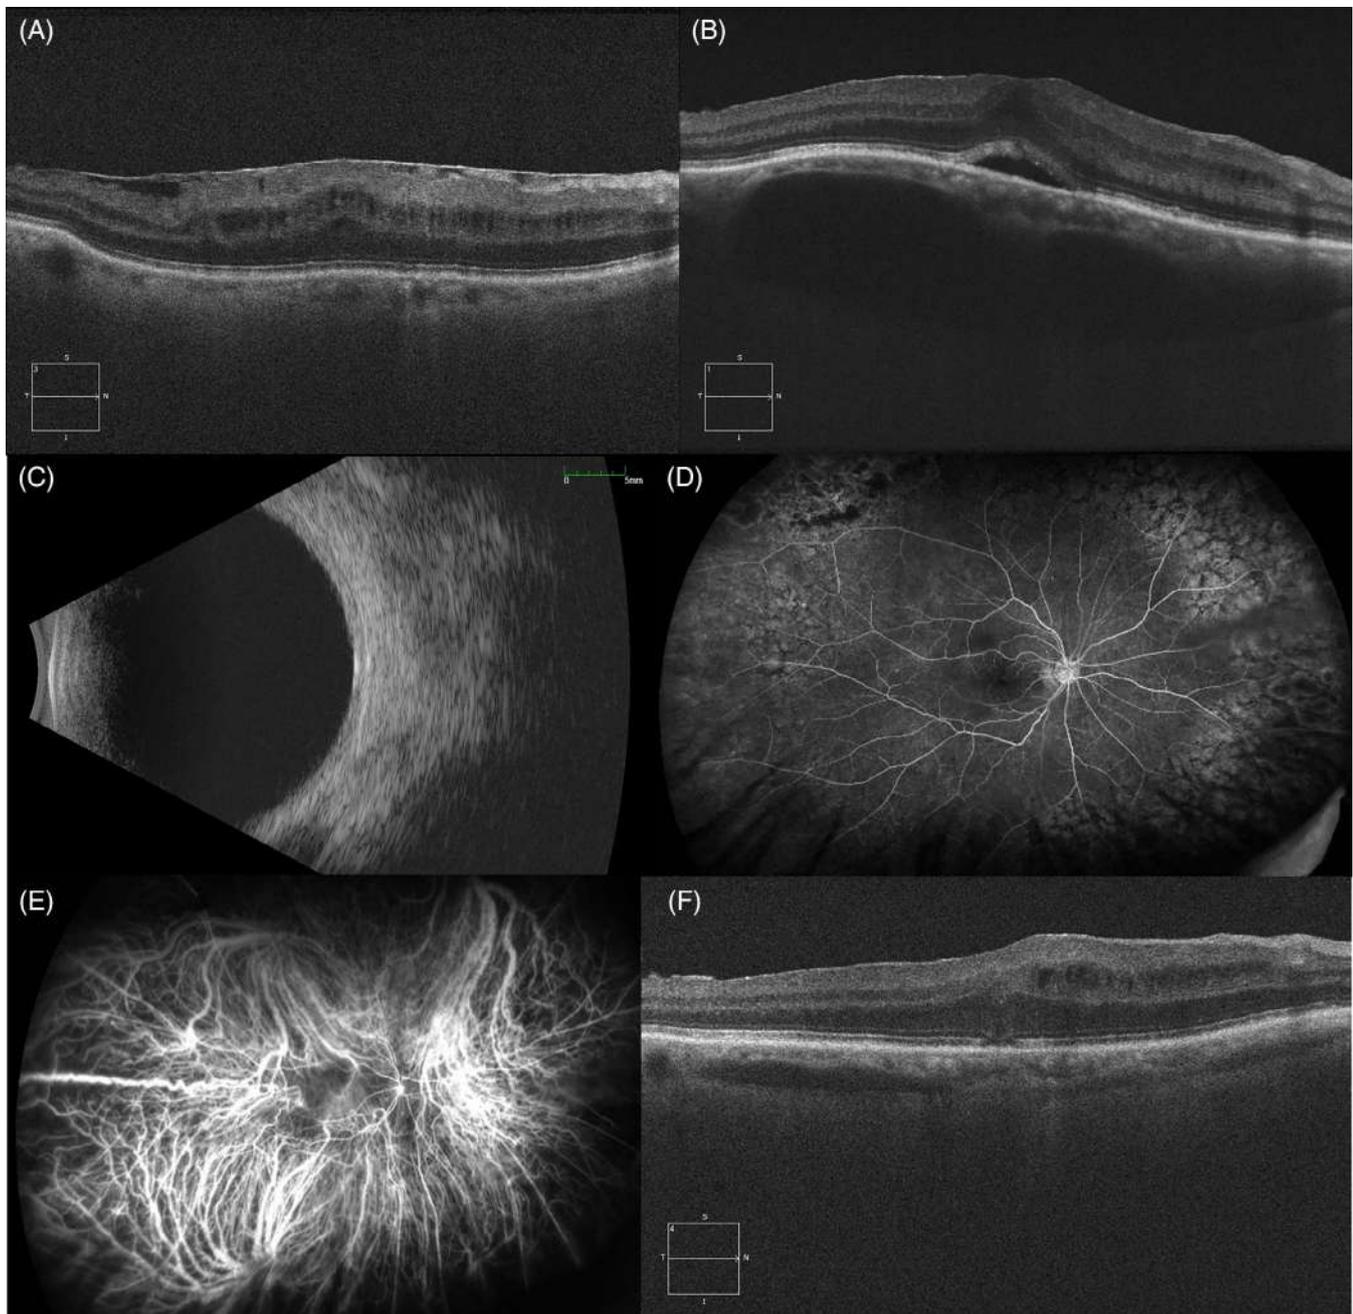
A, Optical coherence tomography (CIRRUS 5000 HD-OCT, Carl Zeiss Meditec AG, Jena, Germany) of the right macula demonstrating an ERM and mild cystoid macular oedema. Subfoveal choroidal thickness is 176 μm . B, One week after vitrectomy surgery with ERM peeling and subtenon triamcinolone acetonide injection, there is subfoveal fluid consistent with central serous chorioretinopathy. The outer choroid is massively thickened with pachyvessels in Haller's layer. The subfoveal choroidal thickness has increased to 703 μm . C, B-scan ultrasonography (Eye Cubed, Ellex, Mawson Lakes, Australia), and D, ultra wide-field fluorescein angiography (Optos PLC, Dunfermine, UK) are normal but E, indocyanine green angiography demonstrates reduced filling of the inferonasal vortex vein, in the same location as where the subtenon triamcinolone was injected. F, Two-months post-operatively the subfoveal fluid has resolved and the choroid has almost returned to normal thickness (213 μm)
